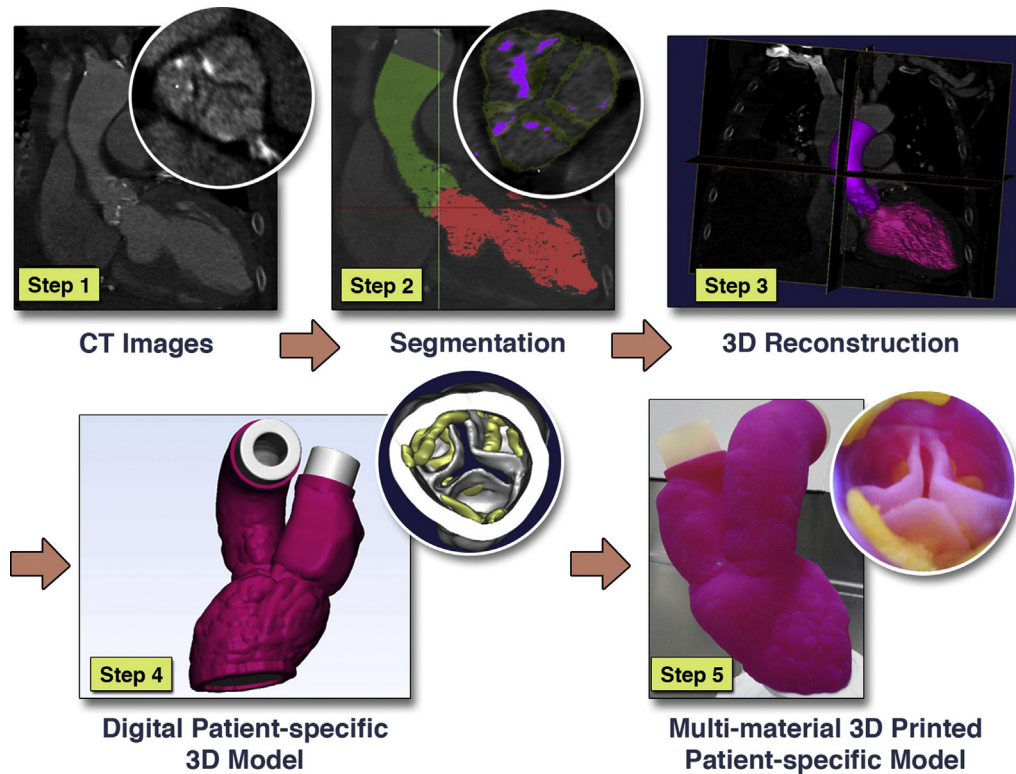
3D-printing technique. Step 1: Data acquisition via CT. Step 2: Segmentation processing of anatomy. Step 3: 3D reconstruction. Step 4: Adjusted digital 3D patient-specific model. Step 5: 3D-printed patient-specific model. *CT*, Computed tomography; *3D*, three-dimensional. Reprinted with permission from Vukicevic and colleagues.⁵
